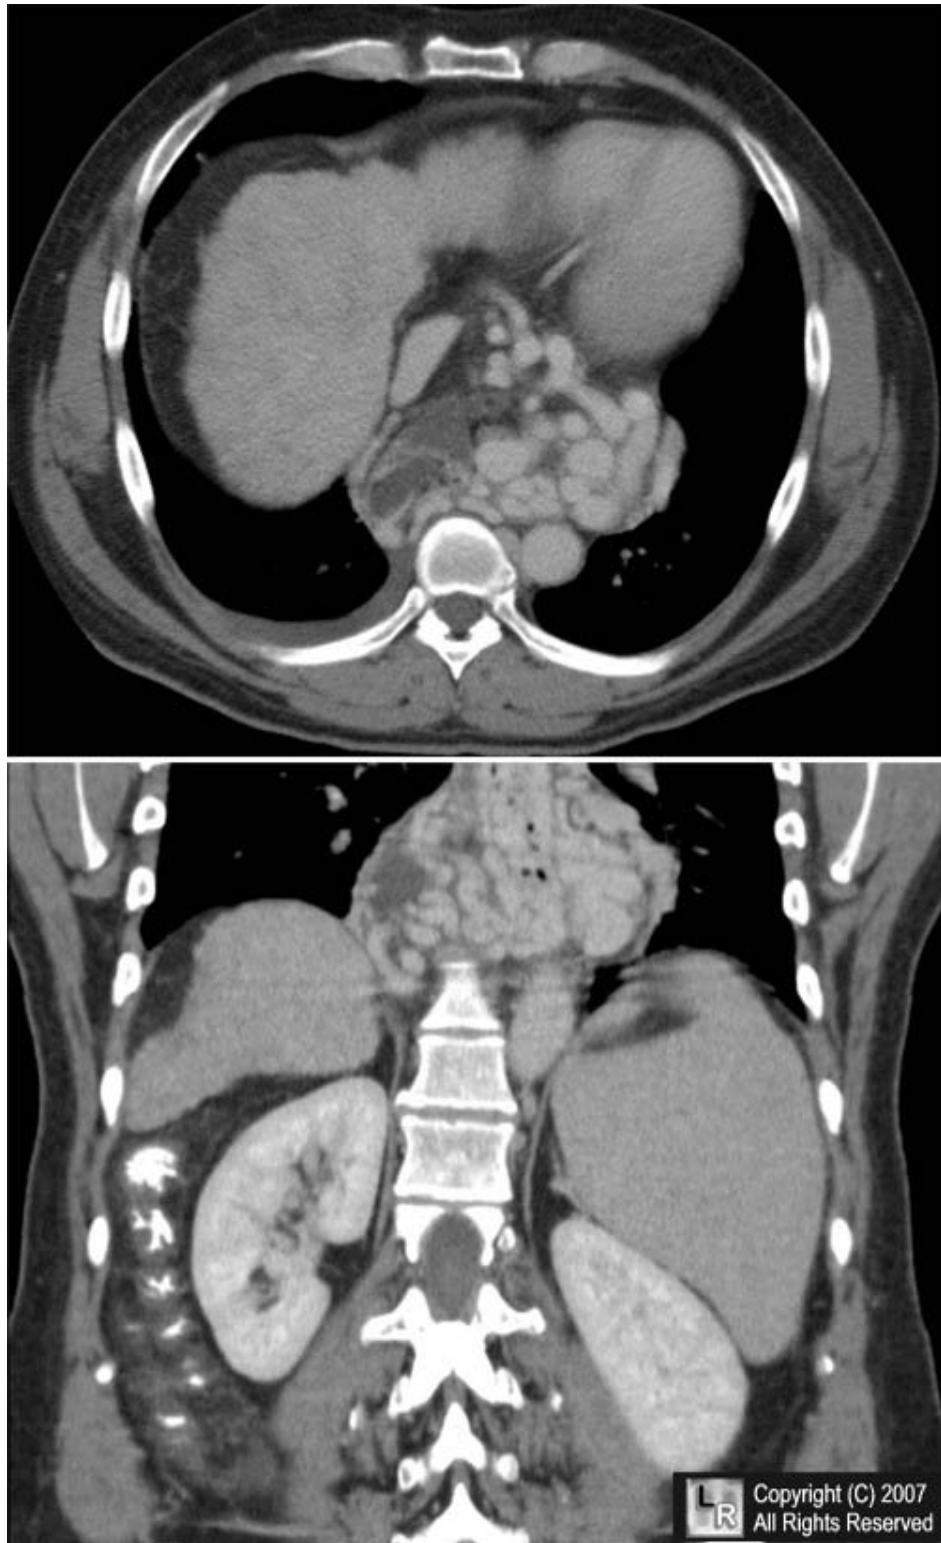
Contrast enhanced CT images (axial and coronal) showing shrunken nodular liver with tortuous gastro-esophageal collaterals and gross splenomegaly.
